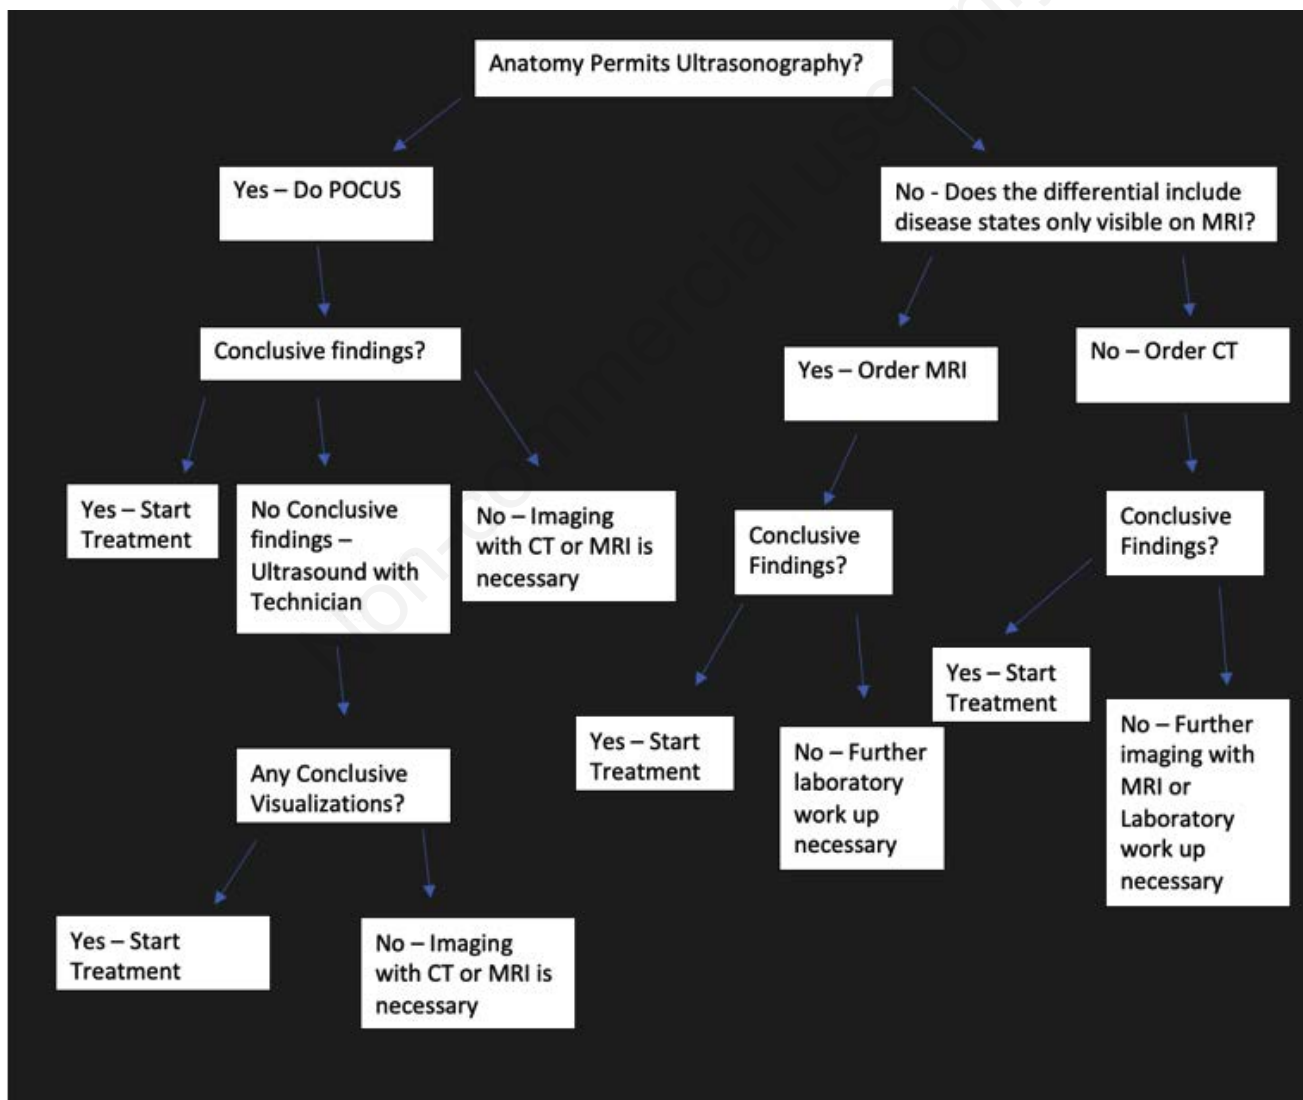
CT: computerized tomography; MRI: magnetic resonance imaging. This algorithm was based on recommendations of general principles from both the Radiological Society of North America and the European Society of Radiology.^{20,21}
